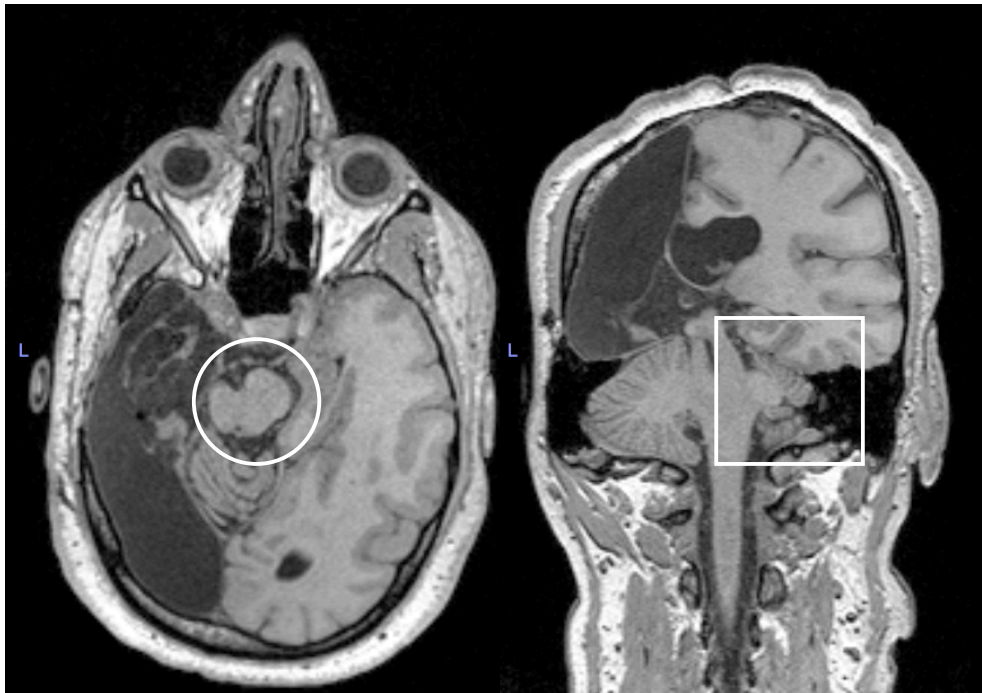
T1-weighted MRI: P.O.
